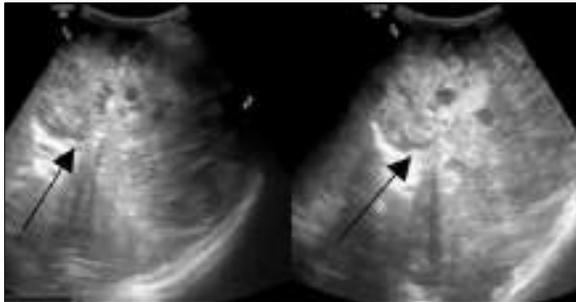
Ultrasound Liver (Black Arrows:Hemangioma)
